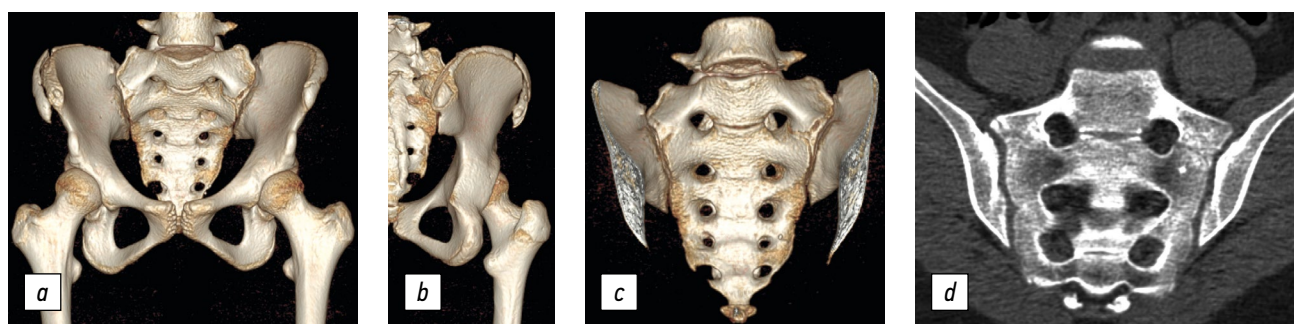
Three-dimensional reconstructions (a, b, and c) and CT scan (d) of the lower lumbar spine, pelvic bones, and hip joints of a 13-year-old female patient. Avulsion fracture of the right iliac crest (a and b). Transitional lumbosacral vertebra, type II, subtype b (a, c, and d).
